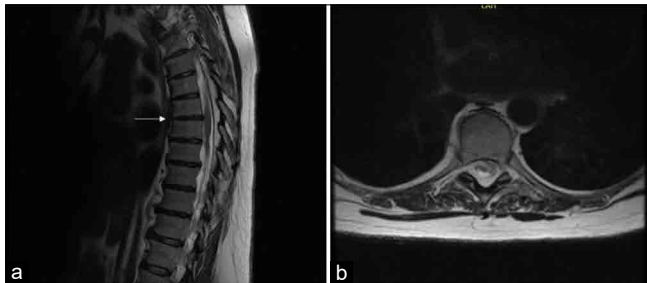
Preoperative MRI thoracic spine. (a) Sagittal view; arrow pointing to the level of the spinal cord herniation at T7-8, (b) Axial view at the level of the spinal cord herniation T7-8. MRI thoracic spine, T2-weighted sequence.
